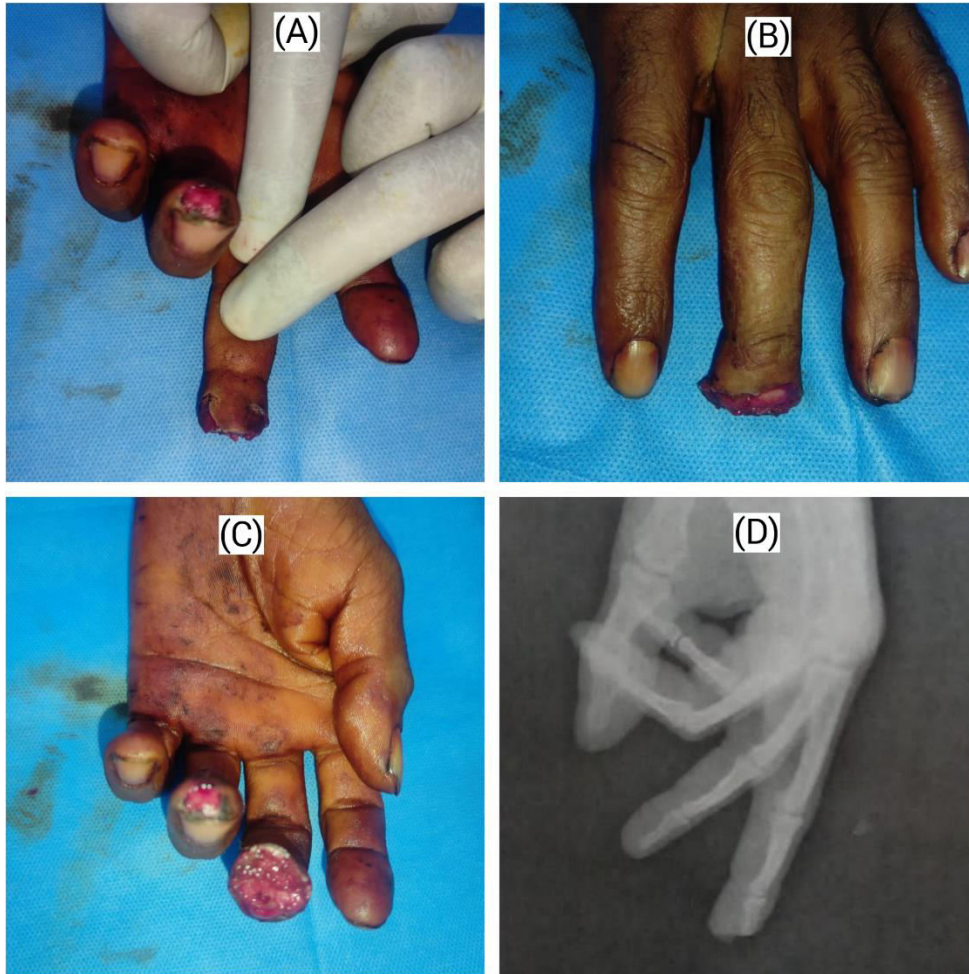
Transverse fingertip injury of left middle finger with bone exposed. (a) volar aspect view. (b) dorsal aspect view. (c) finger tip injury with exposed bone. (d) lateral view hand x-ray.
